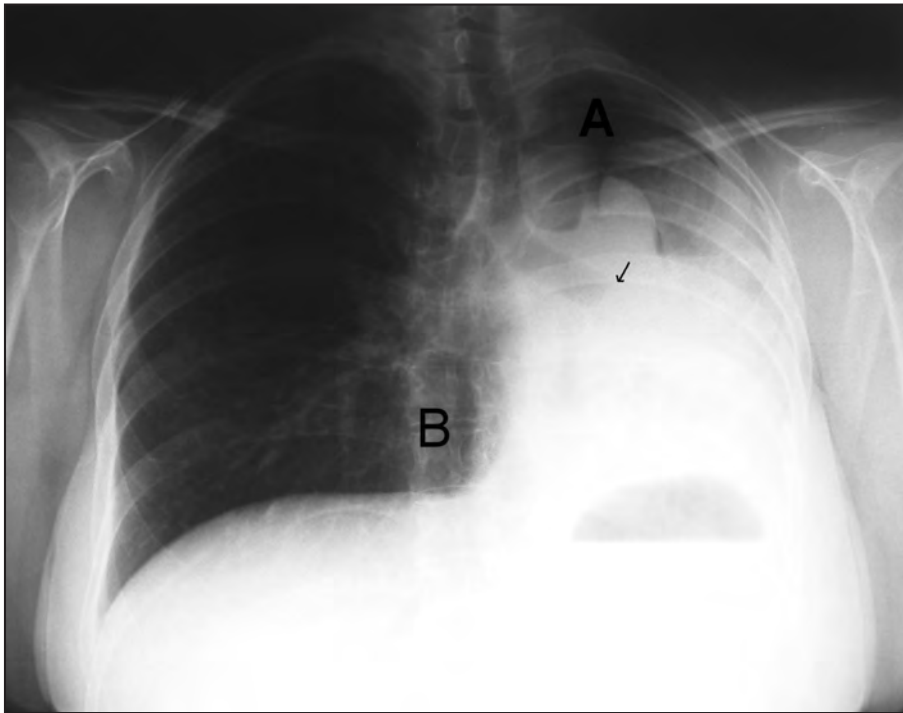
Radiography of posteroanterior thorax showing left lung, left apical pneumothorax (A) and sign of naked spine (B).
